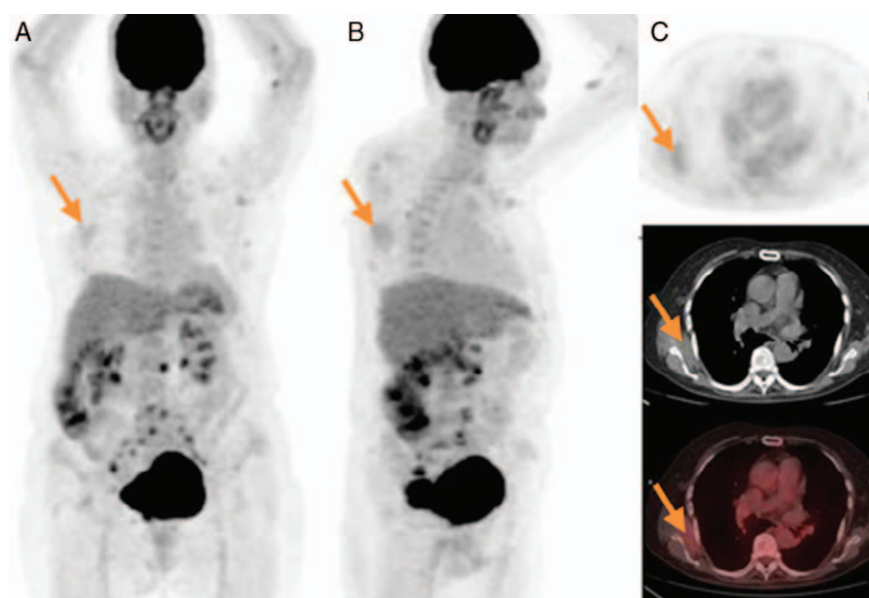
Frontal (A) and lateral (B) MIP projection of a ^{18}F -FDG PET study. Increased FDG accumulation (SUVmax=2.1) on the right posterolateral chest in a patient with metastatic uterine cancer. C) Axial PET and fused PET/CT images demonstrate a right subscapular lesion which corresponds to a unilateral elastofibroma dorsi.
